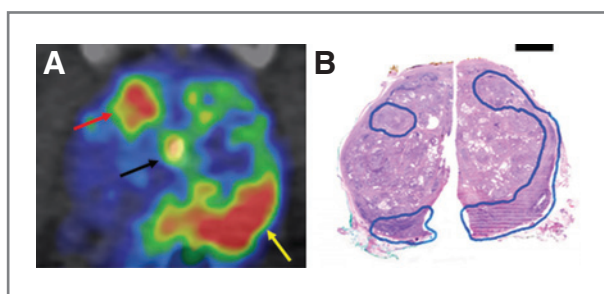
The uptake of BAY86-7548 in patient no. 3 was localized in the peripheral (yellow arrow in A) and central zone (red arrow in A). These areas coincide well with cancer (outlined in blue) on corresponding prostatectomy sections (B, bar, 1 cm). The large BPH nodules in the central zone did not show uptake of BAY86-7548. Black arrow points to urinary activity in a urethral catheter. The weight of the prostate gland immediately after prostatectomy was 152 g. Image is scaled to SUV, with a minimum at 0.5 and maximum at 5.
